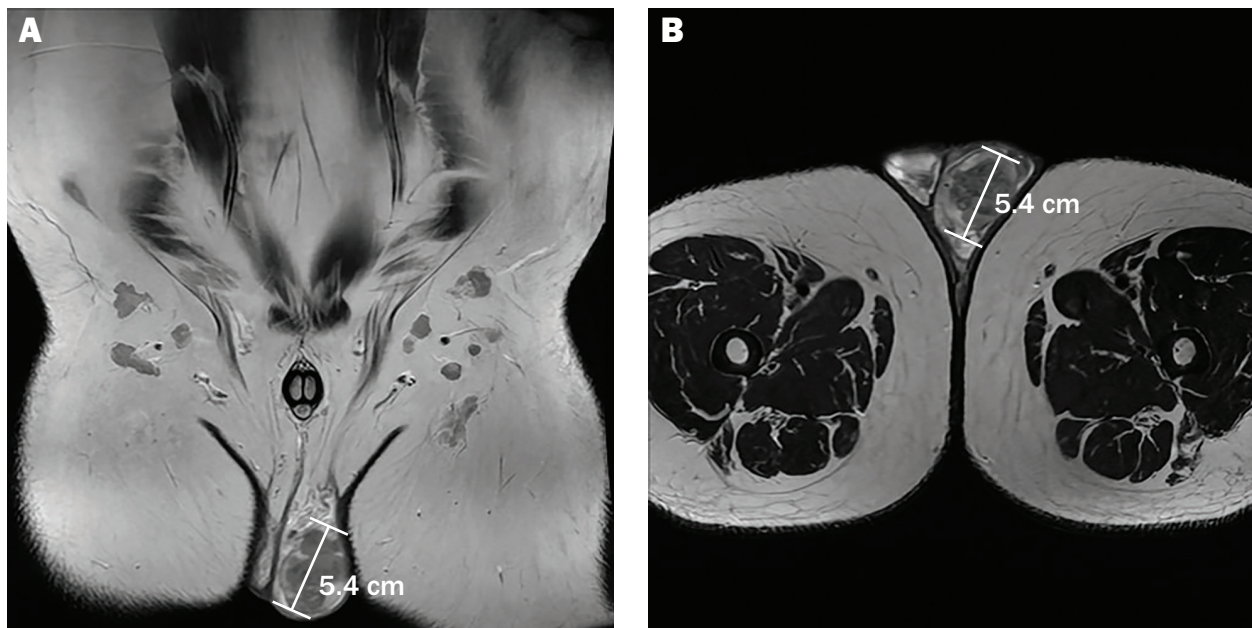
Magnetic resonance image shows (A) coronal and (B) axial windows of a diffuse heterogeneous mass within the left testicle (5.4×3.8 cm).
